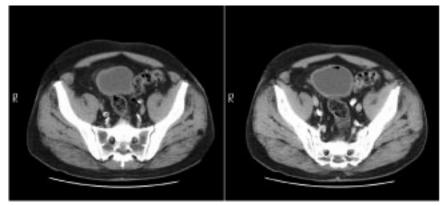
Computed tomography scan of the pelvis, revealing sigmoid diverticula with close adherence to the right posterior and left lateral walls of the bladder (left) and the presence of gas within the bladder (right).
